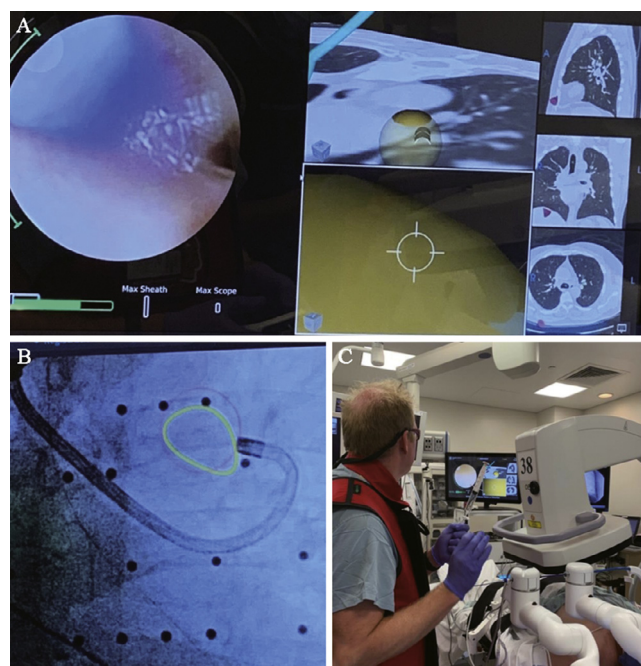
Monarch sampling in the periphery. (A) The left part of the image is the real-time scope view in the periphery demonstrating the ability to see the needle sheath against the wall with needle penetration. The ability to see your instruments in the periphery is key to ensure sample quality. The screens on the right demonstrate the virtual targeting and the single slice CT view to help confirm location. (B) Fluoroscopic view of the Monarch getting ready to sample. (C) The operator is able to control the robot and the instrumentation while utilizing any additional technologies (X-ray, radial endobronchial ultrasound, etc.). CT: Computed tomography.
